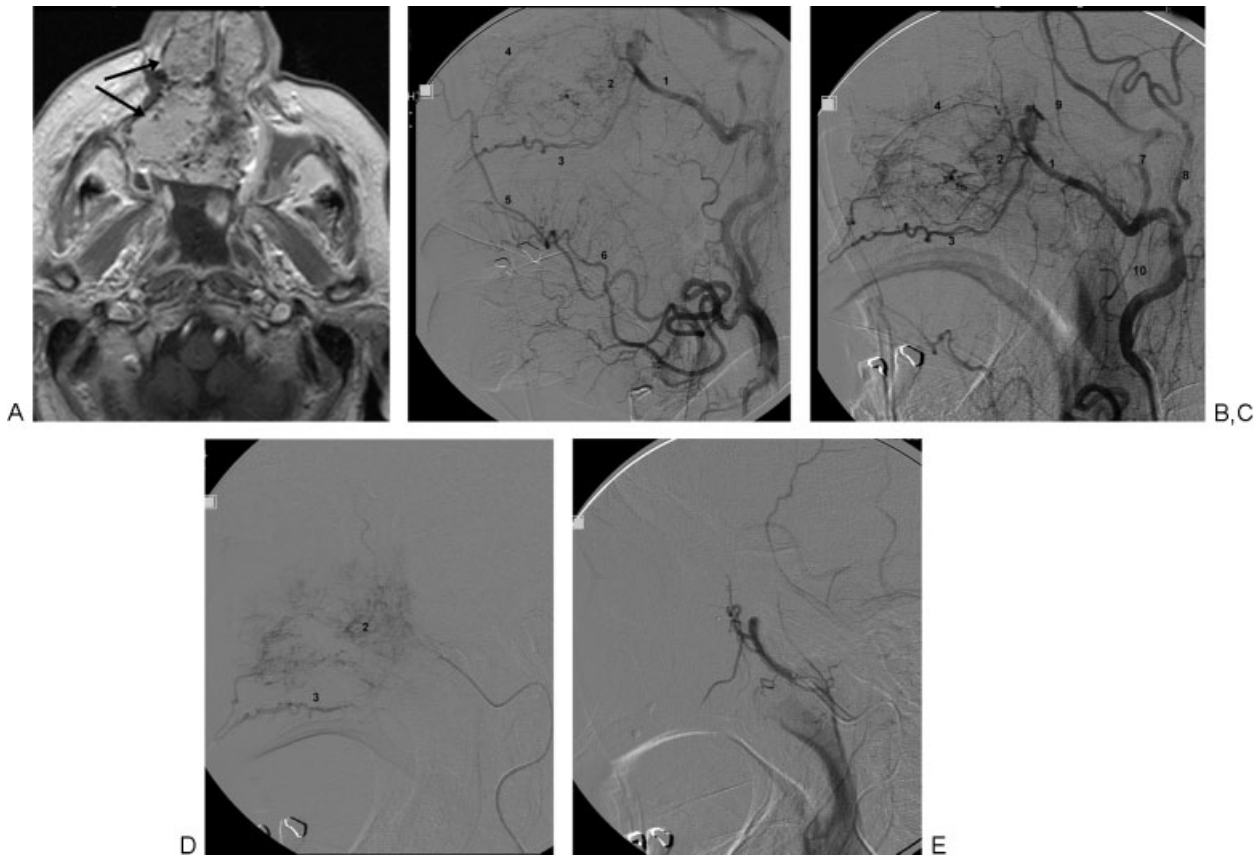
Patient with epistaxis and extensive infiltration of the nasal cavity from adenoid cystic tumor. (A) MRI depicts extensive infiltration by tumor (arrows). (B) and (C) Proximal right ECA injection. Note the extensive vascularity and hyperemia in the area of the SPA artery branches. (D) Progressively more selective distal IMAX injection. (E) Post-IMAX embo appearance. Key: 1—distal IMAX, 2—SPA branches, 3—DPA/GPA relatively large, 4—IOA noted to be relatively small, 5—FA with large distal branches, 6—lingual artery, 7—MMA with characteristic turn as it passes through foramen spinosum, 8—STA with typical hairpin loop as crosses zygoma, 9—middle deep temporal artery, 10—inferior alveolar artery. DPA, descending palatine artery; ECA, external carotid artery; FA, facial artery; GPA, greater palatine artery; IOA, infraorbital artery; MMA, middle meningeal artery; SPA, sphenopalatine artery.
